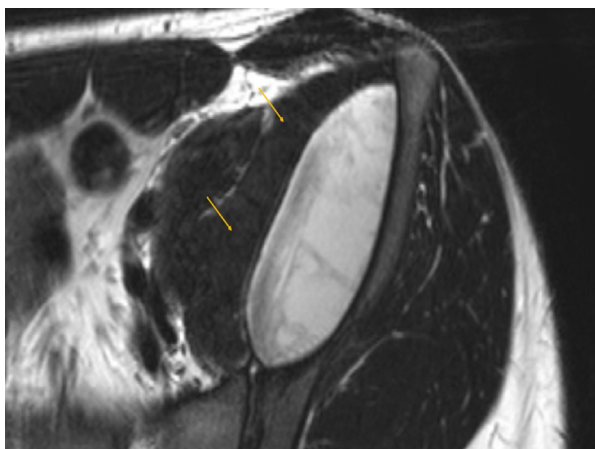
T2-weighted axial image of the pelvis. Again, the arrows denote a well-circumscribed, hyperintense, elliptical lesion between the left iliac bone and left iliacus muscle.
